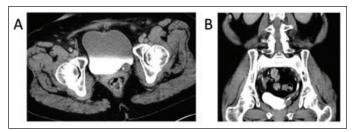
Case 3: Computed tomography urogram showing a soft tissue mass centered on wall of distal left ureter as evidenced by the filling defect on the excretory phase. (A) Axial view, delayed phase; (B) coronal view, delayed phase.
